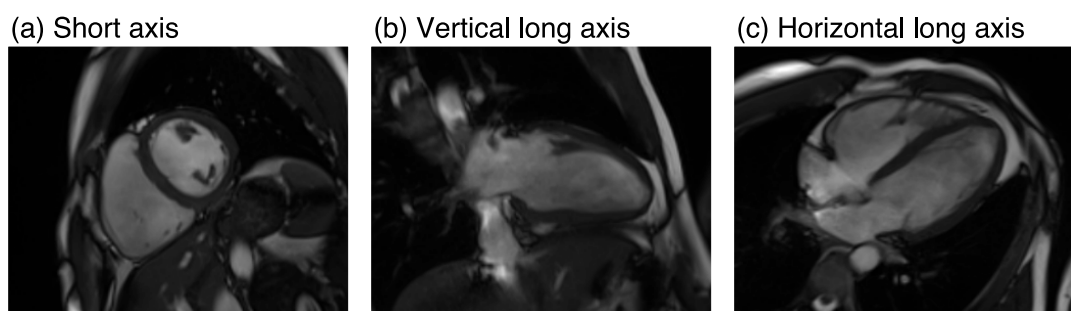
Example orthogonal cardiac planes for 3D MR imaging, showing (a) a short axis slice, (b) vertical long axis and (c) horizontal long axis view.
